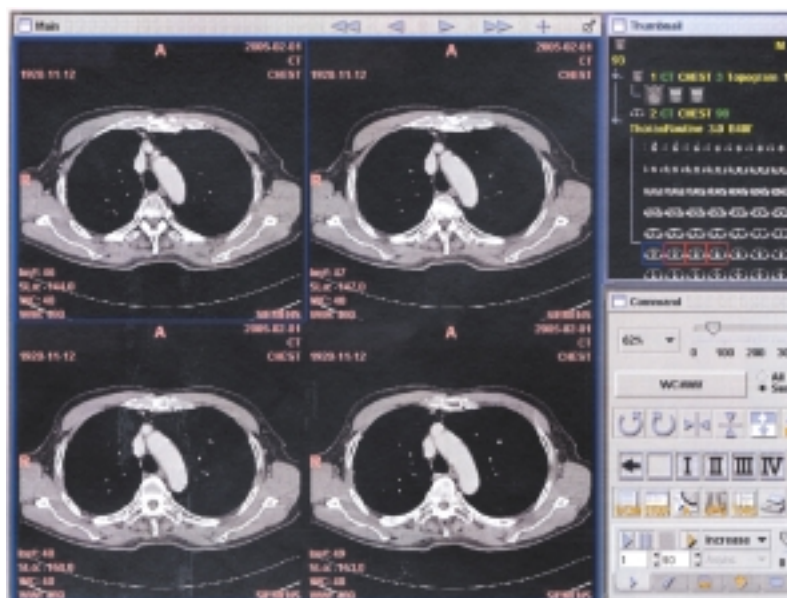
CT images are displayed by the Web DICOM viewer.
